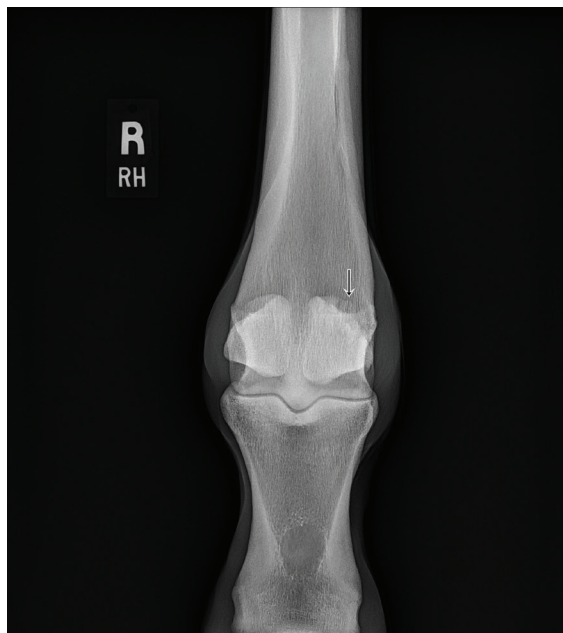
Post-operative (20 wk) X-ray scan of the medial sesamoid bone (arrow points to SBL).
